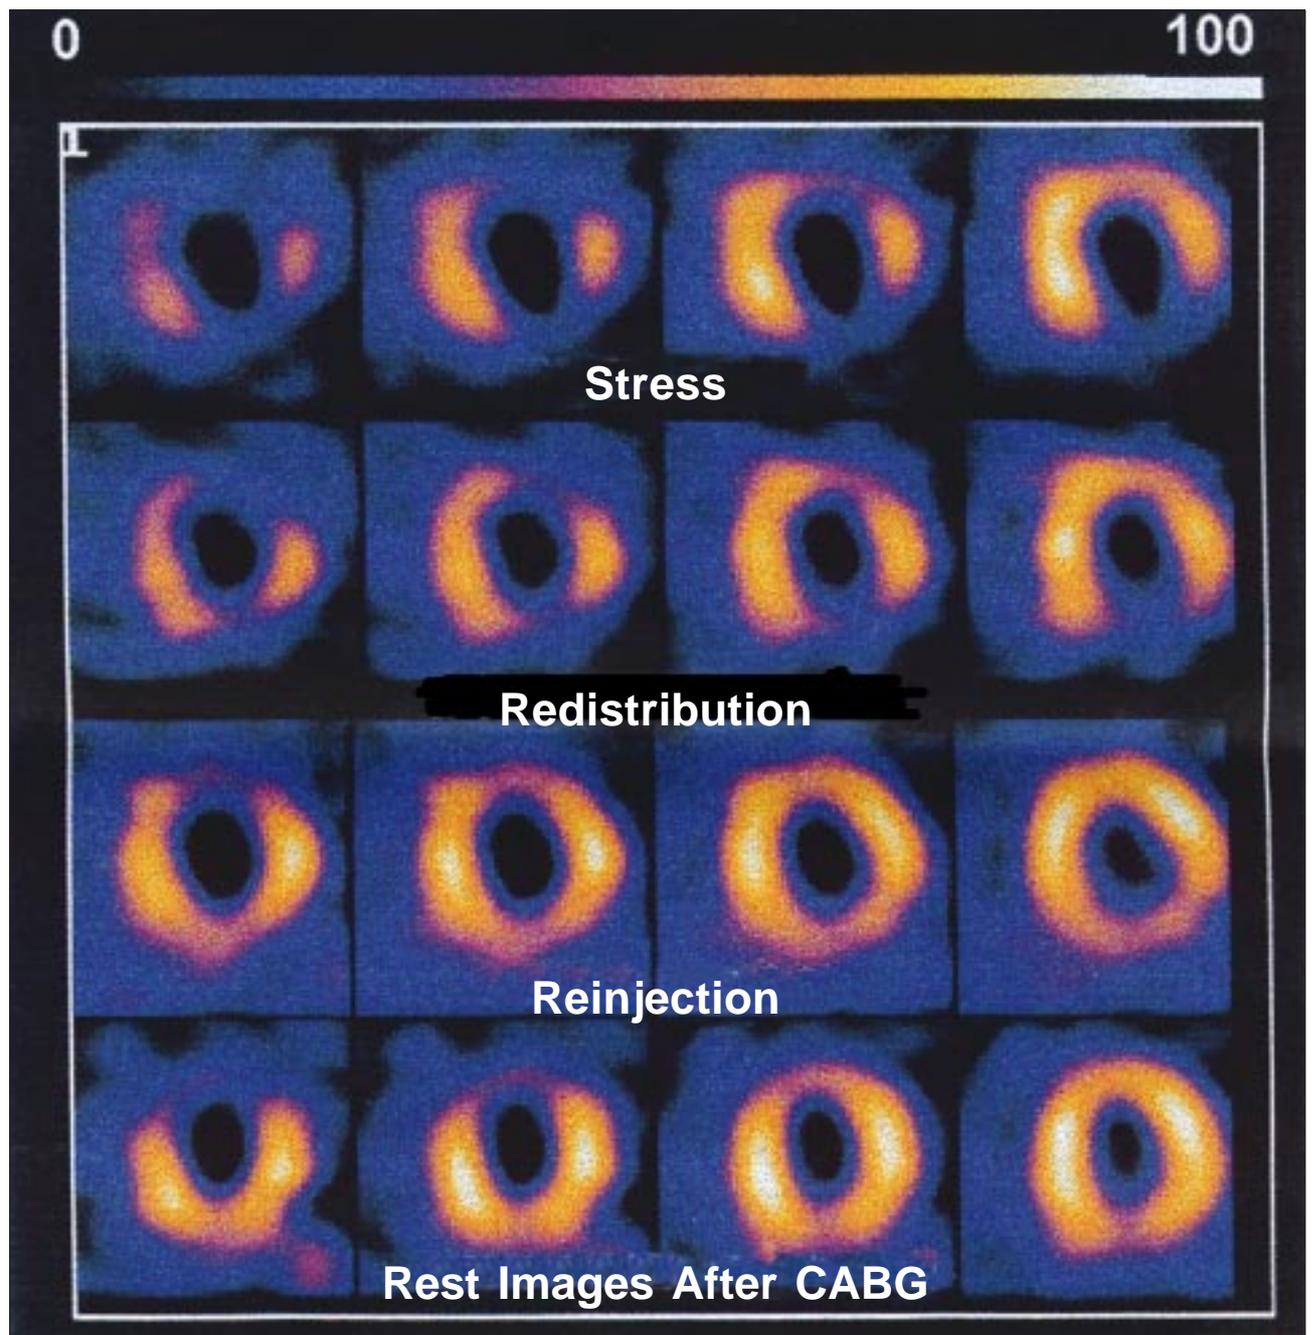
Myocardial perfusion scintigraphy with ^{201}Tl and tomographic slices in the oblique plan. Redistribution images suggest viability in the anterior and lateral regions; reinjection suggest viability of the inferior wall.
